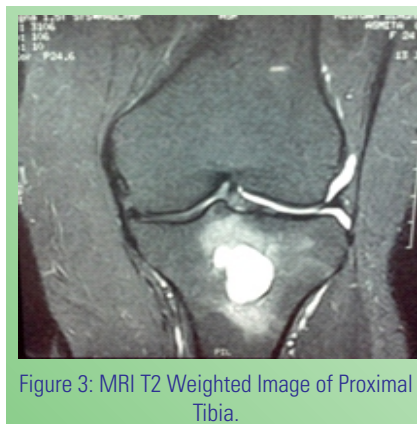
MRI T2 Weighted Image of Proximal Tibia.
